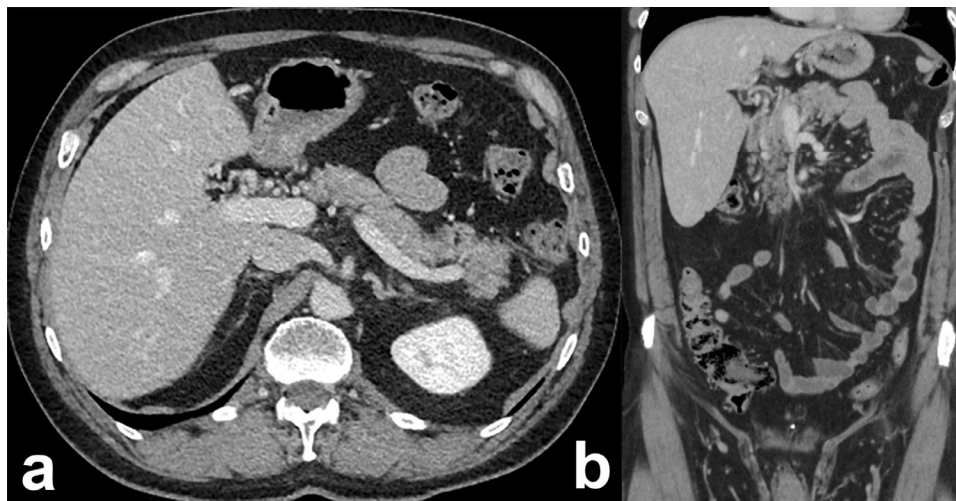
(A) Progressive regression of the PVT with complete regrading of the thrombus in the confluence, vena portae, and regredience of the thrombus in the superior mesenteric vein in the CT after 6 months. (B) In the coronal reconstruction, complete regression of the wall swelling in the left lower abdomen located in small intestine loops.
